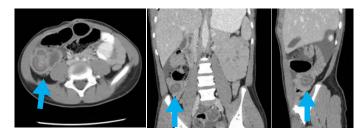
Showing the target sign on the computed tomography scan (blue arrow)
